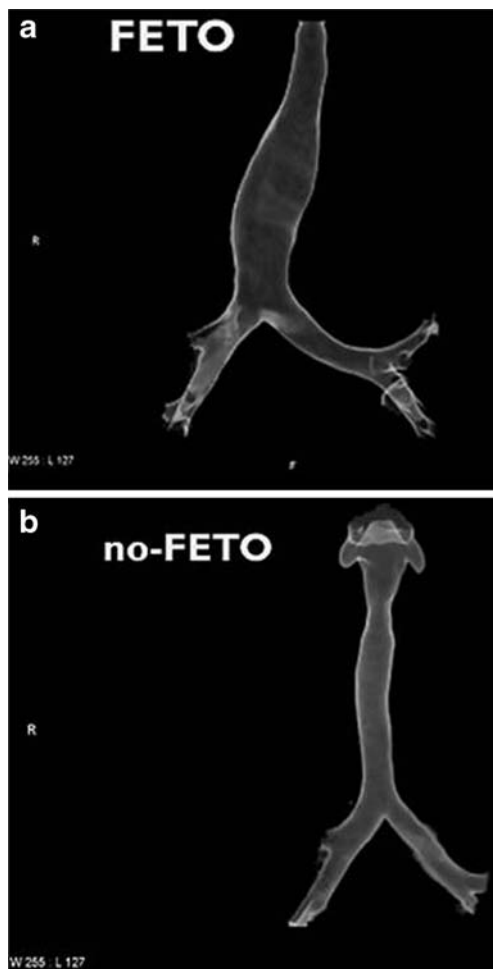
Comparison of a 3-D reconstruction of the trachea of a child between 4.5 and 5 years of age either (a) having undergone FETO or (b) expectantly managed during pregnancy, both asymptomatic. The FETO patient (a) has distal tracheal widening as compared to the control (b). Low-dose/ 2 mGy spiral chest CT was performed with the child in a supine position and during quiet respiration at near functional residual lung capacity. CT parameters: tube voltage 100 kVp, tube load 45 mAs, collimation 64×0.6 mm, pitch 1.4, rotation time 0.5 s and CTDIvol 2 mGy. The upper limit of the field of view was situated at the vocal cords and the lower limit at the base of the lungs (Somatom Sensation 64, Siemens Medical Solutions, Erlangen, Germany)
